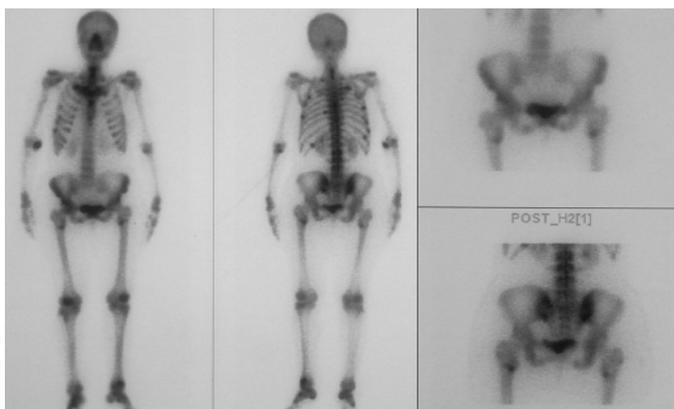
Bone scintigraphy revealed increased activity involvement in multiple ribs, both superior pubic rami and inner margins of the femoral neck that were compatible with pseudofractures.
